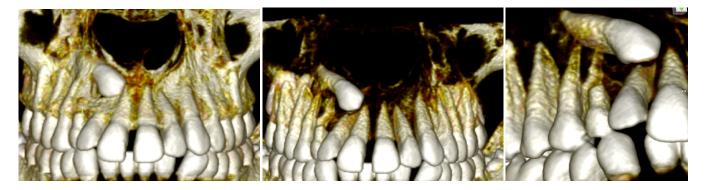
Volumetric reconstructions of cone beam tomography
